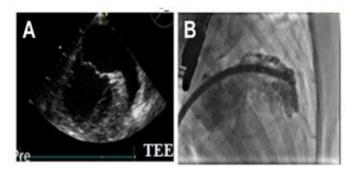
A) Pre implantation of watchman device in heart transesophageal echocardiography (TEE) reports. B) The Angiogram image of LAA, pre-implantation of device. [7]
